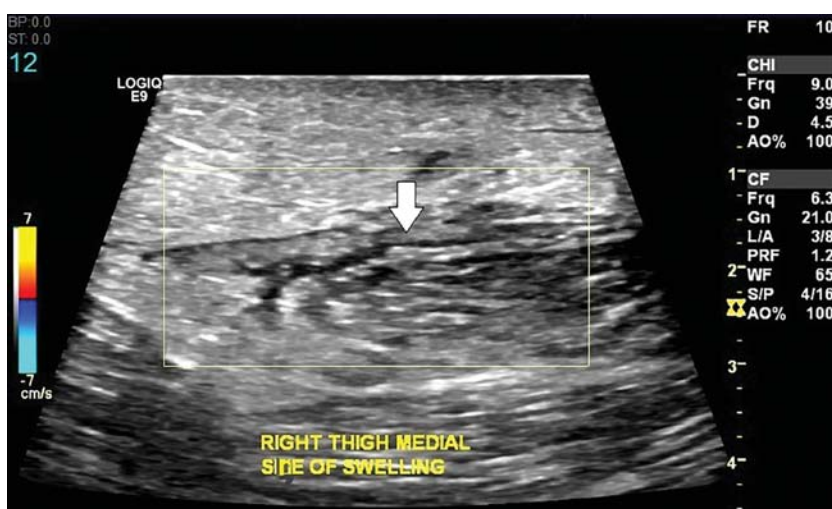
Ultrasound scan of the right thigh swelling showing hypoechoic area of inflammation with serpiginous echogenic structures (arrow).
